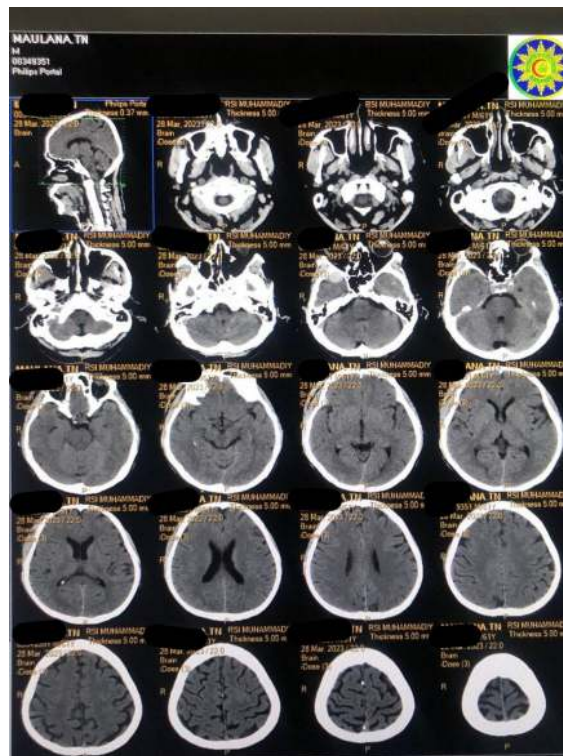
CT Scan Image of the Head Axial Bone Window
